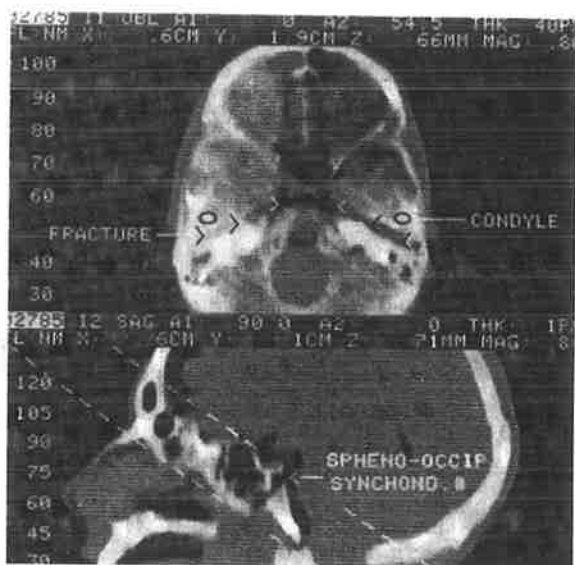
Reformatted CT scan of skull base.
